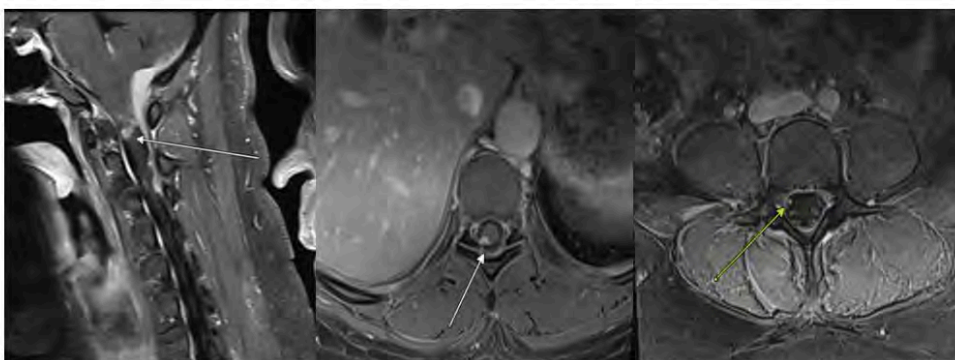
MRI of the spine demonstrating nodular intramedullary and dorsal cord lesions with leptomeningeal involvement of cauda equina nerve roots.
